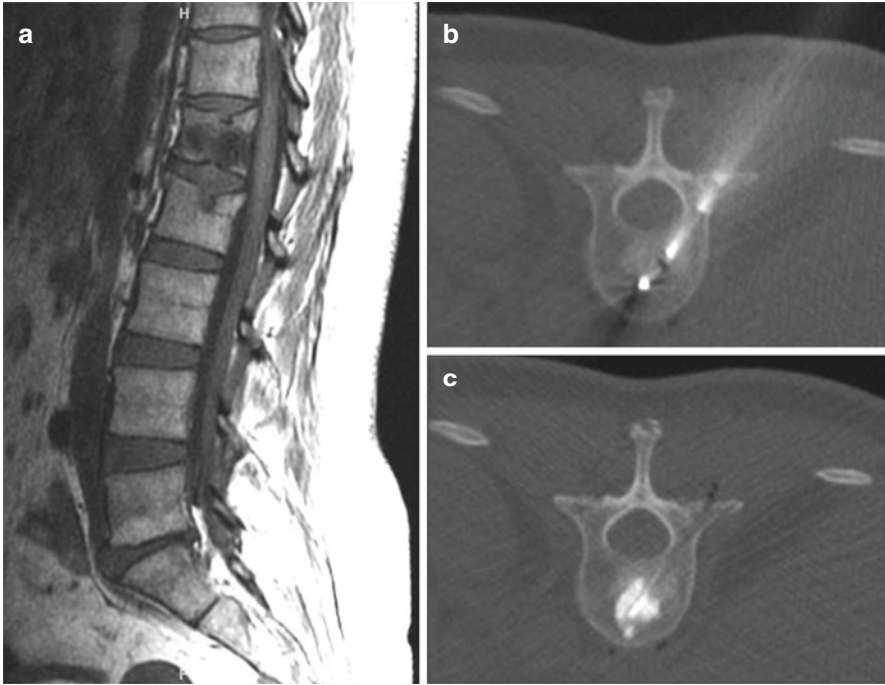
Sagittal T1 (a) demonstrating a T1 hypointense metastasis in the L1 vertebral body. Axial procedural CT images (b and c) show the DFINE STAR ablation device entering the vertebral body via a transpedicular approach with deployment of the curved RF cannula (b). Following the ablation, cement augmentation is administered (c)
